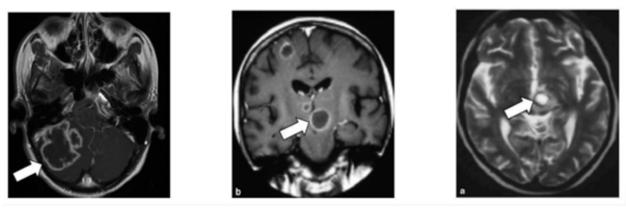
MRI brain showing tuberculous abscesses
